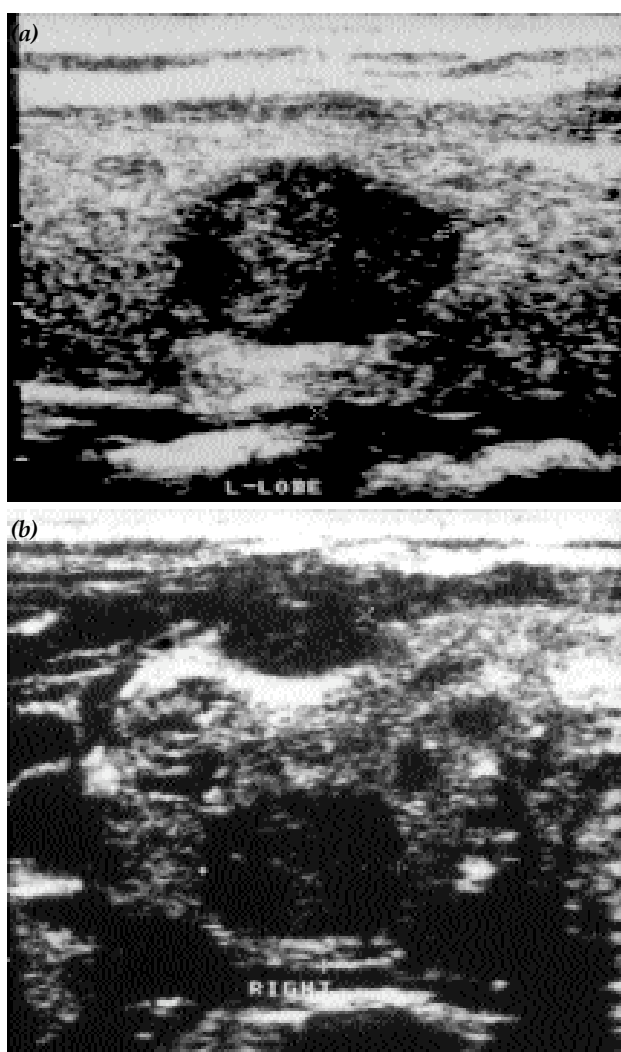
Ultrasonography of the thyroid. Multiple nodules (a) in the left and (b) right lobes.
